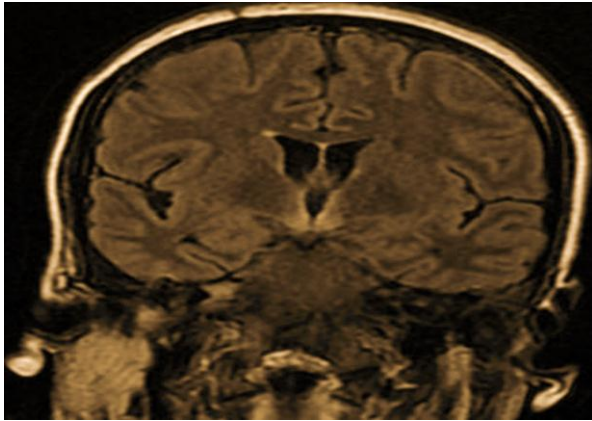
Brain MRI sequence in FLAIR showing symmetric hyper signal at the level of the mammillary bodies.
